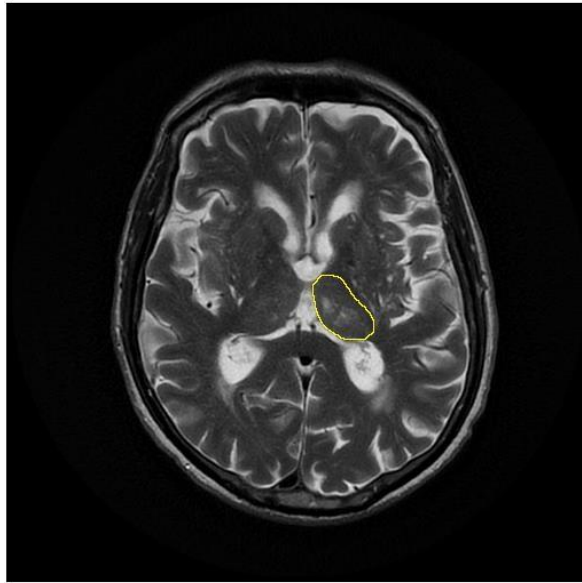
Segmentation of the left thalamus on an MRI image from our case series.
